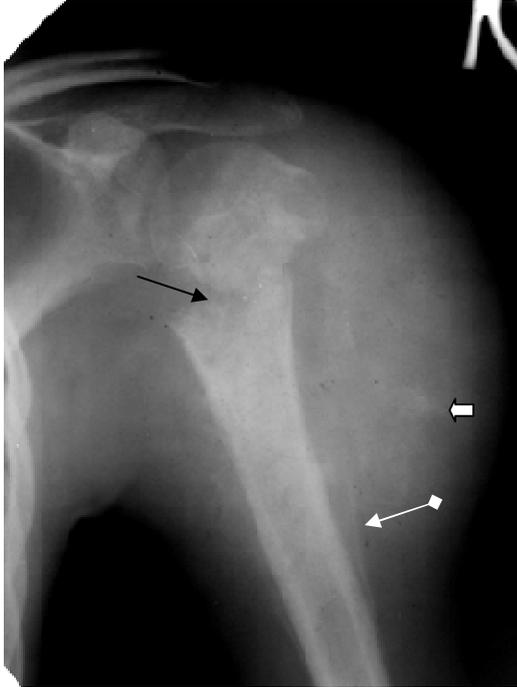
Enlargement radiograph of the humeral joint in a direct projection. In area of proximal epiphysis and humeral bone metaphysis a there is destruction with pathological fracture and cross-section displacement of fragments (arrow). Pathological osteogenesis, extending to the soft tissue, without accurate contours, increase of shoulder soft tissues (a figured arrow). Codman's triangle (arrow with rhombus). Osteosarcoma of the humeral bone with pathological fracture.
